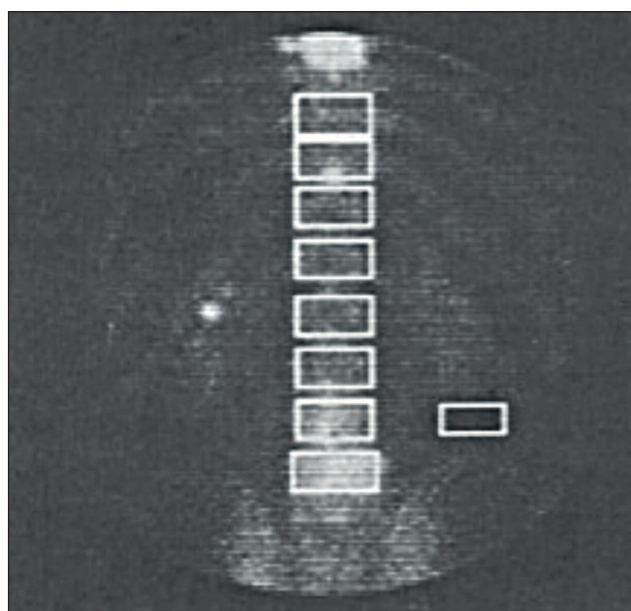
"Dynamic quantitative bone scintigraphy": A ROI was defined over each vertebra from T10 to L5; background region was placed between the projection of the kidney and crista iliaca [5].
